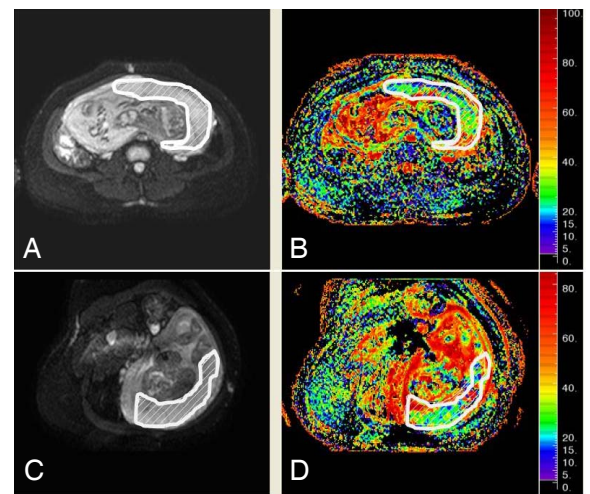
Axial DWI of the mid placenta (A) and PF map (B) in the supine position and axial DWI of the of the mid placenta (C) and PF map (D) in the LLD position. ROIs drawn over the placenta show increased PF in the LLD position (38%) versus the supine position (24%).
